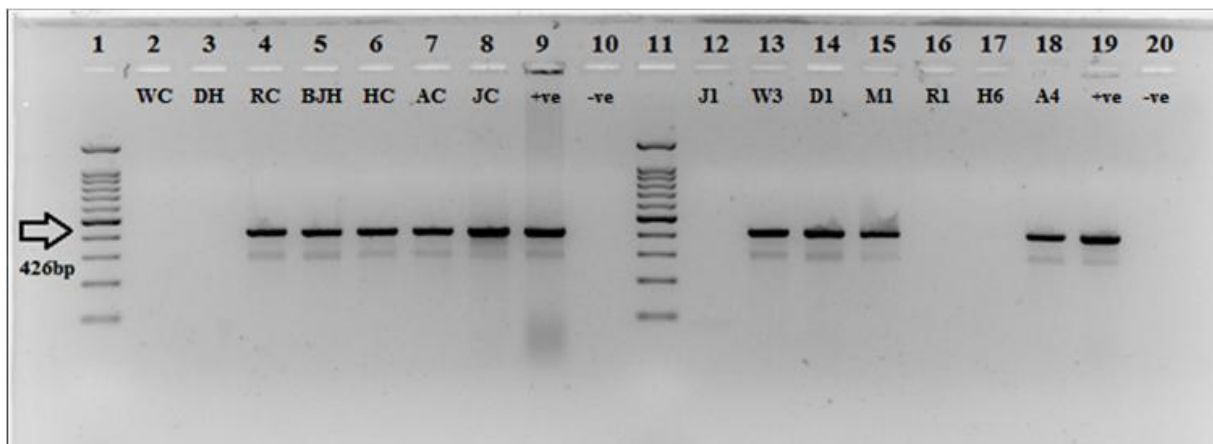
Representative 16S rRNA PCR using Lgsp primer of DNA from hospital samples. Lane 1 represents 100bp ladder. Lanes 2 to 8 represent sandwich filter samples (water samples), positive with 426bp and negative results. Lane 9, positive control (*Legionella feeleii* -L2-). Lane 10, negative control (*E.coli*). Lane 11 represents 100bp ladder. Lanes 12 to 18 represent biofilm swab samples, positive with 426bp and negative results. Lane 19, positive control (*Legionella pneumophila* subsp. *pneu.* Philadelphia-L4-). Lane 20, negative control (DW). WC: Al-Watani cold water, DH: Rafidia hot water, RC: Ramallah cold water, BJH: Beit Jala hot water, HC: Al-Ahli cold water, AC: Alia cold water, JC: Jenin cold water, J1: Jenin operation shower hose, W3: Al-watani pharmacy faucet, D1: Rafidia burn faucet, M1: Al-Makassed labor outside faucet, R1: Ramallah X-Ray faucet, H6: Al-Ahli CCU shower hose, and A4: Alia operation faucet 1. Complete data are shown in (Appendix E).
